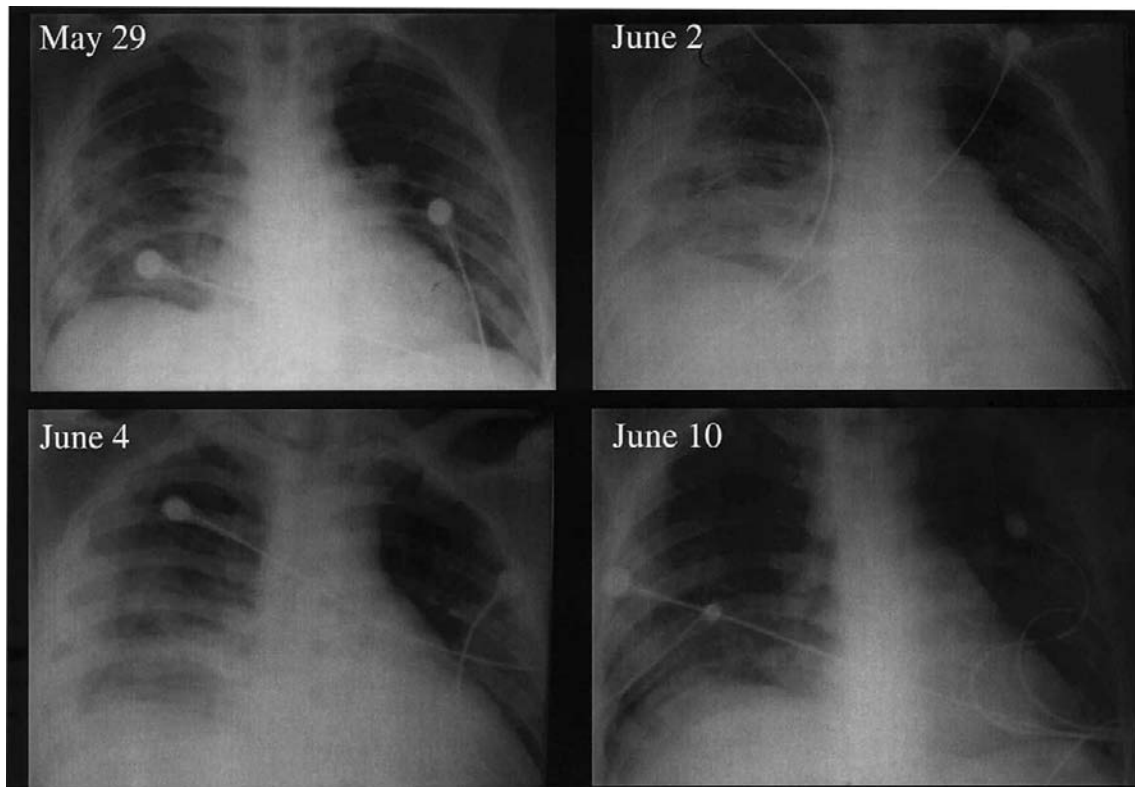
Chest radiographs from one patient showing the progression of pneumonia (*top left and right*, 29 May and 2 June, respectively), the effect of 8 h of inhaled NO therapy (*lower left*, 4 June), and the effect after 1 week of treatment, with a decrease in the pneumonia infiltrates (*lower right*, 10 June). *Top left*, Shadows with blurred margins bilaterally and a normal heart size; *top right*, shadows have increased in extent and density (pleural effusion can be seen on the right side), and there is marked bulging of the pulmonary artery segment (suggestive of pulmonary hypertension) and an increased heart size; *lower left*, extension and density of shadows are similar to those in the radiograph from 2 June; however, the pulmonary artery segment has become flatter, indicating a reduction in pulmonary artery pressure during the inhaled NO treatment; *lower right*, densities are reduced bilaterally, and the heart size is almost normal.
